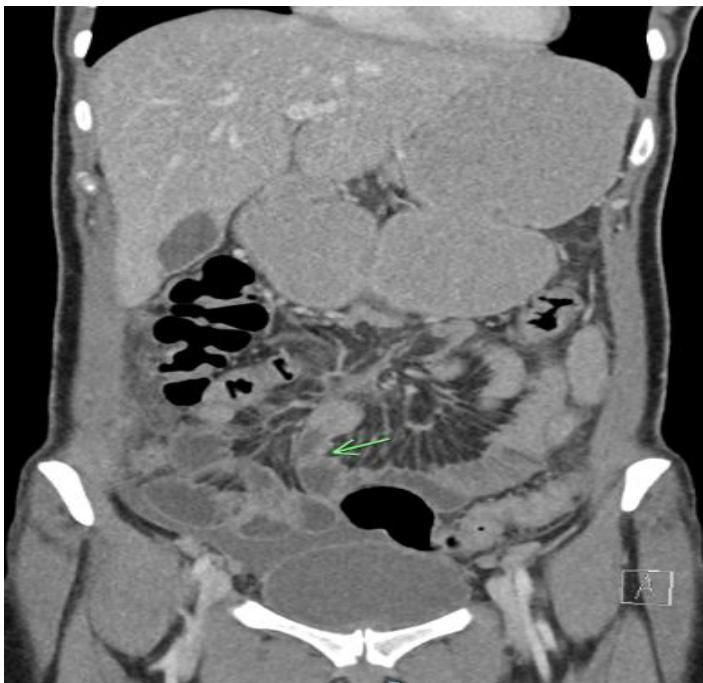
Coronal view on CT scan showing another transition point
